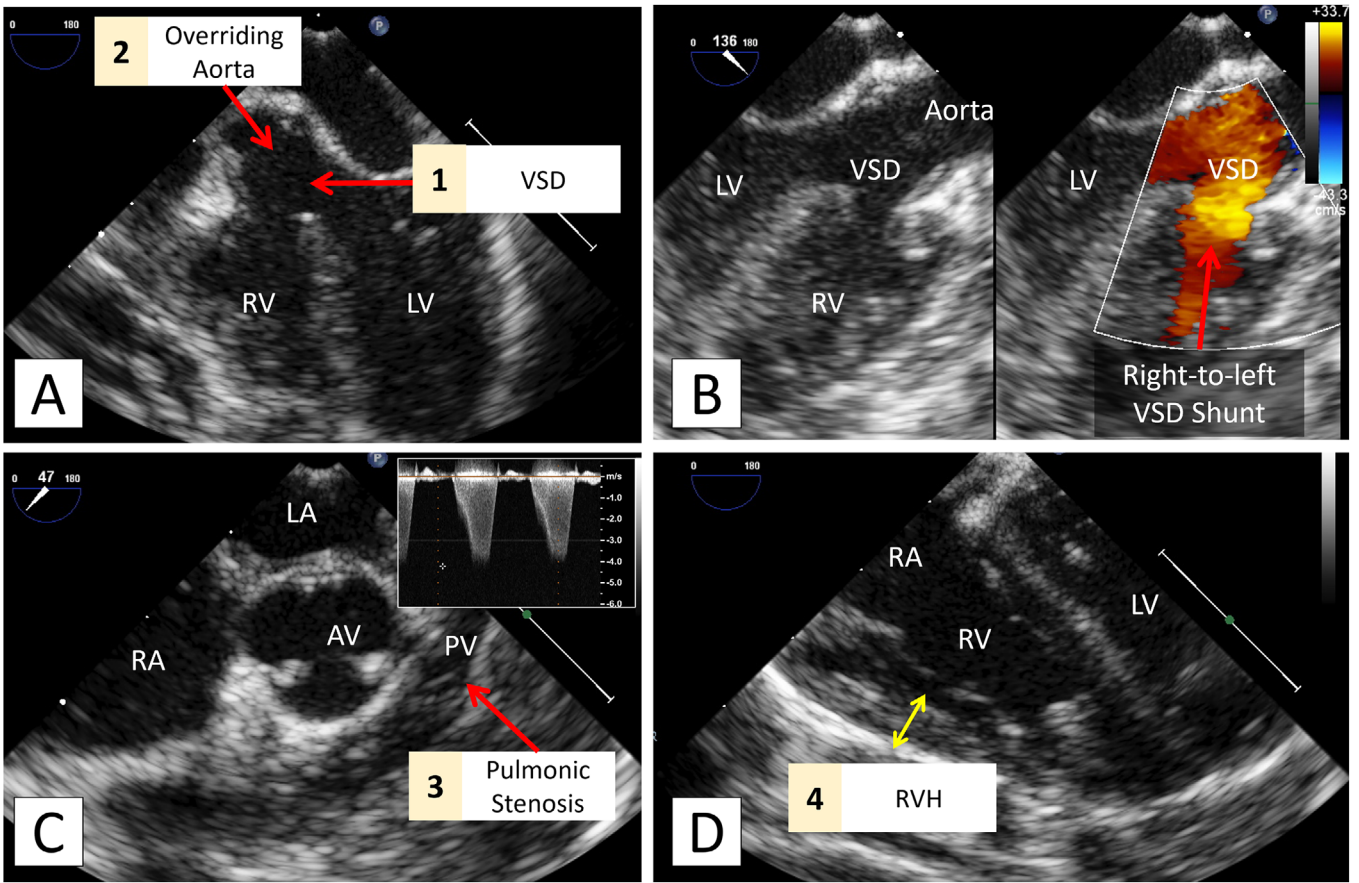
Classic tetrad of unrepaired TOF on TEE Panel A: Mid-esophageal five-chamber view shows the VSD (arrow 1) and overriding of the aorta (arrow 2). Panel B: Modified mid-esophageal views with and without color Doppler demonstrate right-to-left shunt through the VSD. Panel C: Midesophageal short-axis view of the aortic valve. The pulmonic valve leaflets (arrow) are thickened. Spectral Doppler study of the pulmonic valve shows a peak velocity of roughly 4.5 m/s, consistent with severe stenosis. Panel D: Modified view of the right ventricle highlights increased thickness of the RV free wall (double-headed arrow) due to RV hypertrophy. AV, aortic valve; LA, left atrium; LV, left ventricle; PV, pulmonic valve; RA, right atrium; RV, right ventricle; RVH, right ventricular hypertrophy; VSD, ventricular septal defect.
